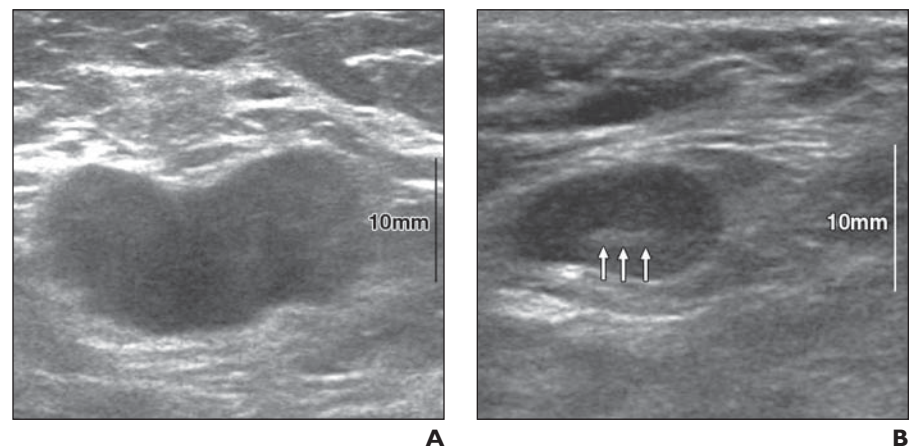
Ultrasound images of metastatic axillary lymph node in patients with infiltrating ductal carcinoma. A, Metastatic axillary lymph node in 49-year-old woman with IDC shows complete absence of fatty hilum. Long- and short-axis measurements are 28 and 12 mm, respectively. B, Metastatic axillary lymph node in 67-year-old woman with IDC shows near complete absence of fatty hilum (arrows). Long- and short-axis measurements are 14 and 8 mm, respectively.
